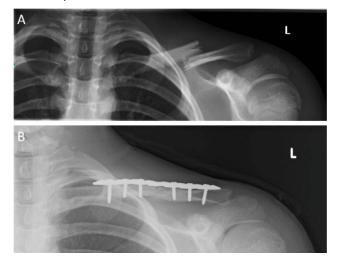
A) Radiograph of a 14-year-old male patient demonstrating OTA 15.2B mid-shaft clavicle fracture with significant shortening. B) Surgical fixation with pre-countered anatomical plate at postoperative 4th week showing bony bridging.
